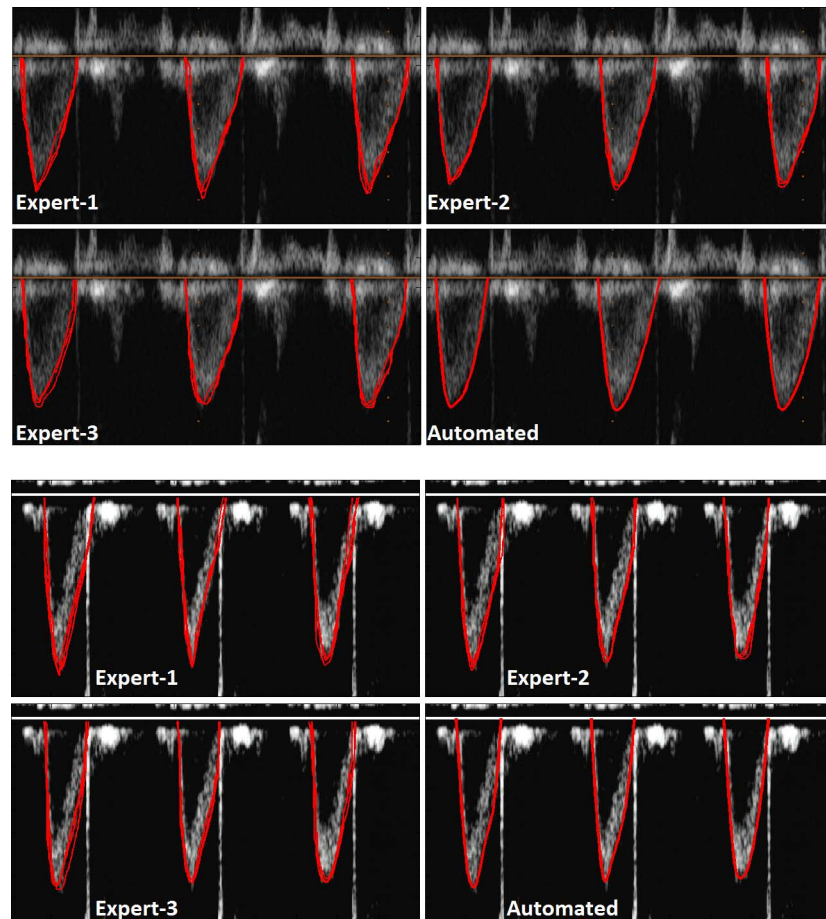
Example Doppler flow velocity curves showing manual traces for all three experts and the automated traces for the same heartbeats collected from Philips (top) and Esaote (bottom) ultrasound scanners.
